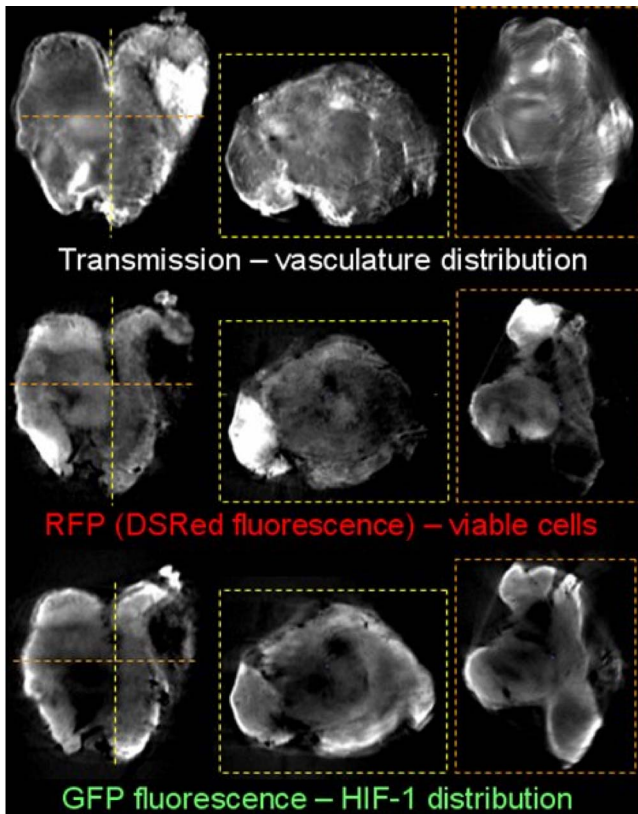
Orthogonal views through 3-D reconstructions of HCT116 xenograft tumor imaged by optical-CT and optical-ECT. The tumors were triply labeled, with RFP and GFP fluorescent reporter proteins, and light absorbing ink in the vasculature. Constitutive RFP labels the viable tumor burden, and GFP labeled HIF1 expression. The upper row is optical-CT images of vasculature. The middle row is optical-ECT images of the RFP (viable tumor) distribution. The lower row is optical-ECT images of the GFP (HIF1) distribution.
